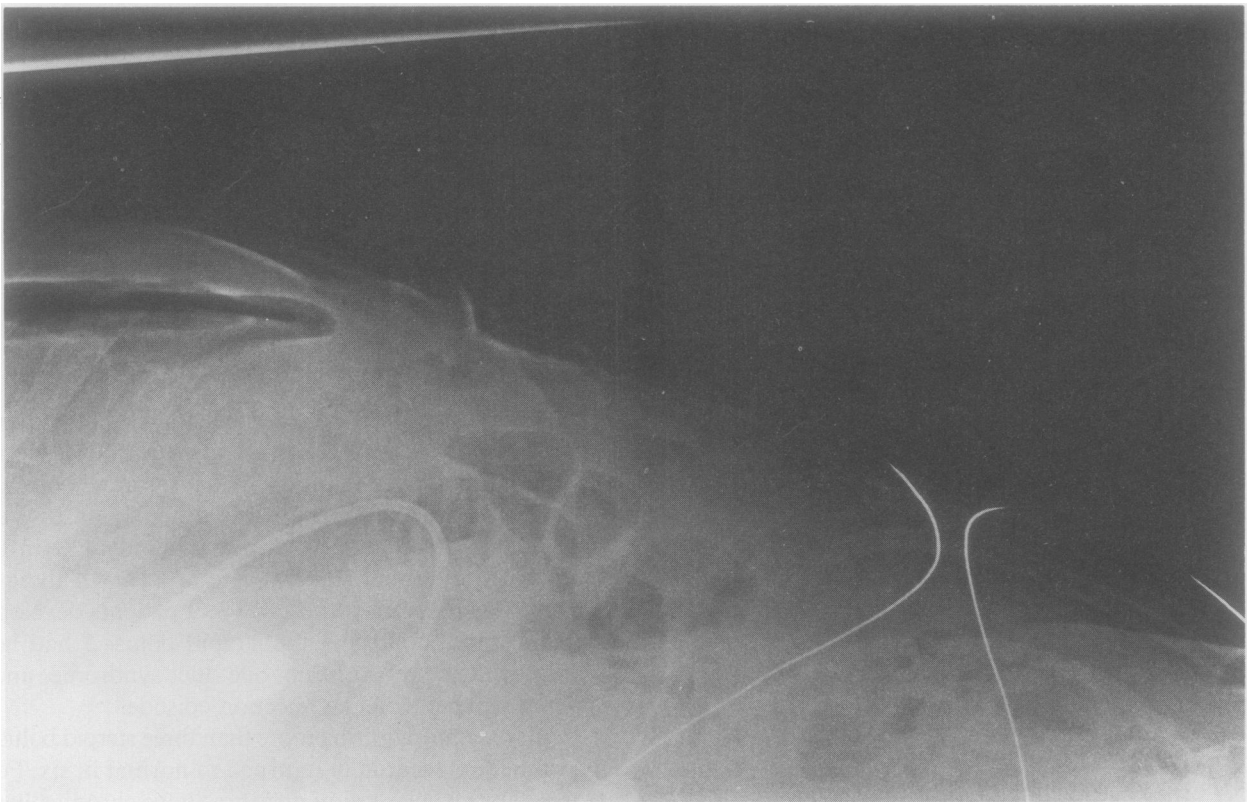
Transtable lateral abdominal x-ray showing free intraperitoneal air in a patient with intestinal perforation.
